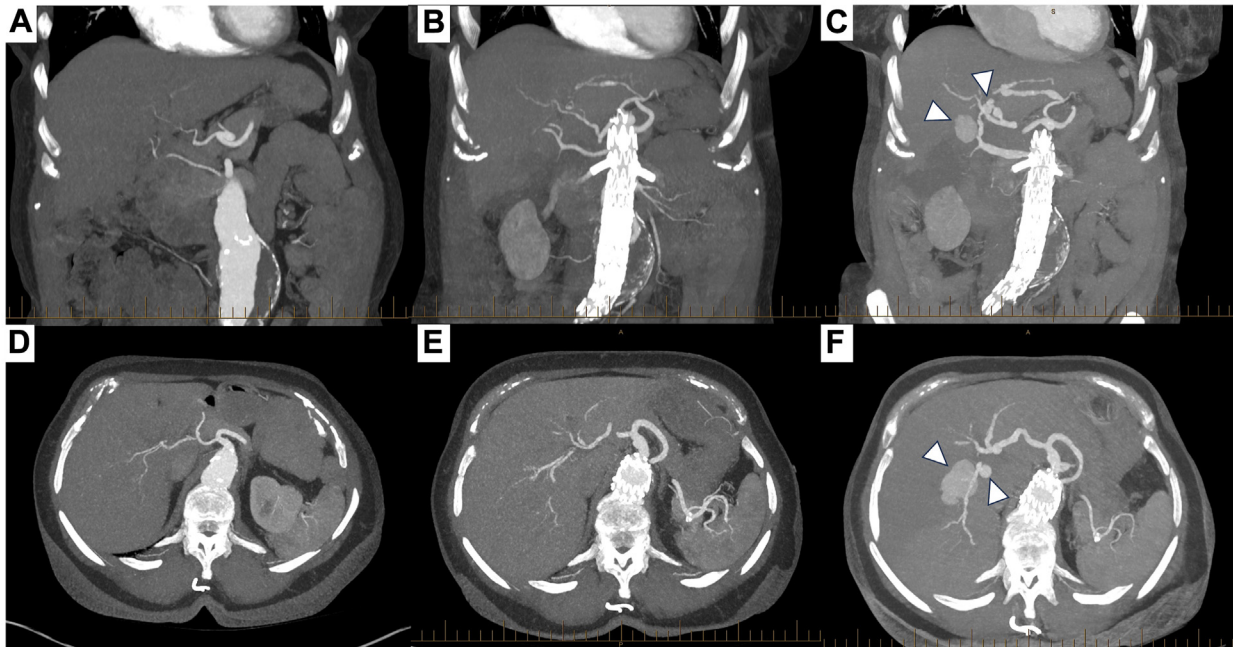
A, Initial preoperative coronal computed tomography angiography (CTA) demonstrating no evidence of aneurysms over the branches of the celiac trunk and hepatic artery. The preoperative juxtarenal abdominal aortic aneurysm can be partially seen at the bottom of the image. B, Readmission CTA over a similar slice again demonstrating no evidence of aneurysms over the branches of the celiac trunk and hepatic artery. The previously partially imaged juxtarenal abdominal aortic aneurysm has been excluded with the presence of a fenestrated endograft in the abdominal aorta. C, A repeat coronal CTA 2 days later over a similar slice demonstrating the presence of multiple new aneurysms over the right hepatic artery (*arrowhead*). D, Initial preoperative axial CTA demonstrating no evidence of aneurysms over the branches of the celiac trunk or hepatic artery. E, Readmission axial CTA over a similar slice again demonstrating no evidence of aneurysms over the branches of the celiac trunk or hepatic artery. A fenestrated endograft is now present in the abdominal aorta. F, Repeat axial CTA 2 days later over a similar slice demonstrating the presence of multiple new aneurysms over the right hepatic artery (*arrowhead*).
